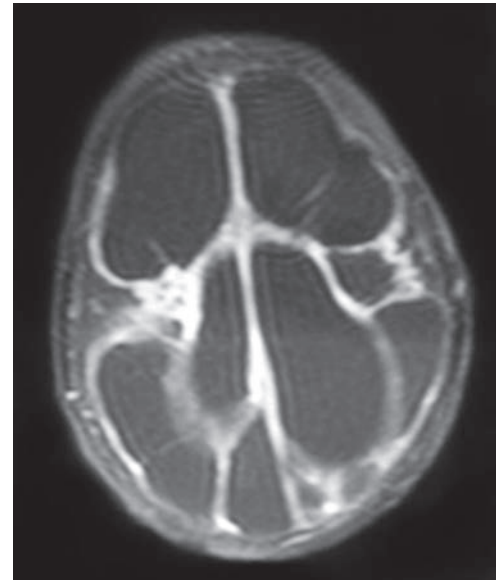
Axial MRI image of brain showing multicystic encephalomalacia in spastic quadriplegic cerebral palsy
